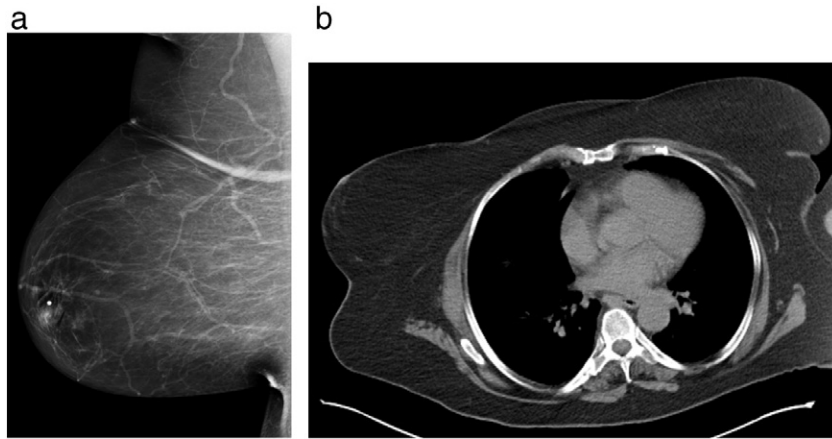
(a) Mammogram of a BI-RADS grade 1 fatty breast. (b) CT of the same person also shows fatty breasts.
